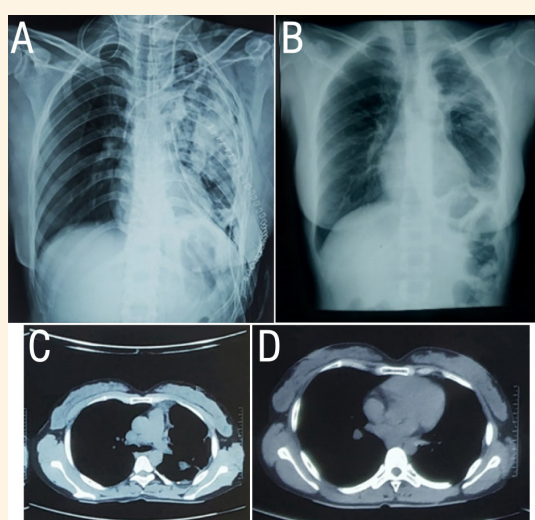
A: Immediate postoperative chest X-ray. B: Chest X-ray posterior-anterior view at follow-up after three months showing completely resolved cystic lesion. C: Computed tomography (CT) of the thorax at the three months follow-up at the level of carina showing no recurrent cystic lesions. D: CT of the thorax at the three months follow-up below the level of carina showing no recurrent cystic lesions.
